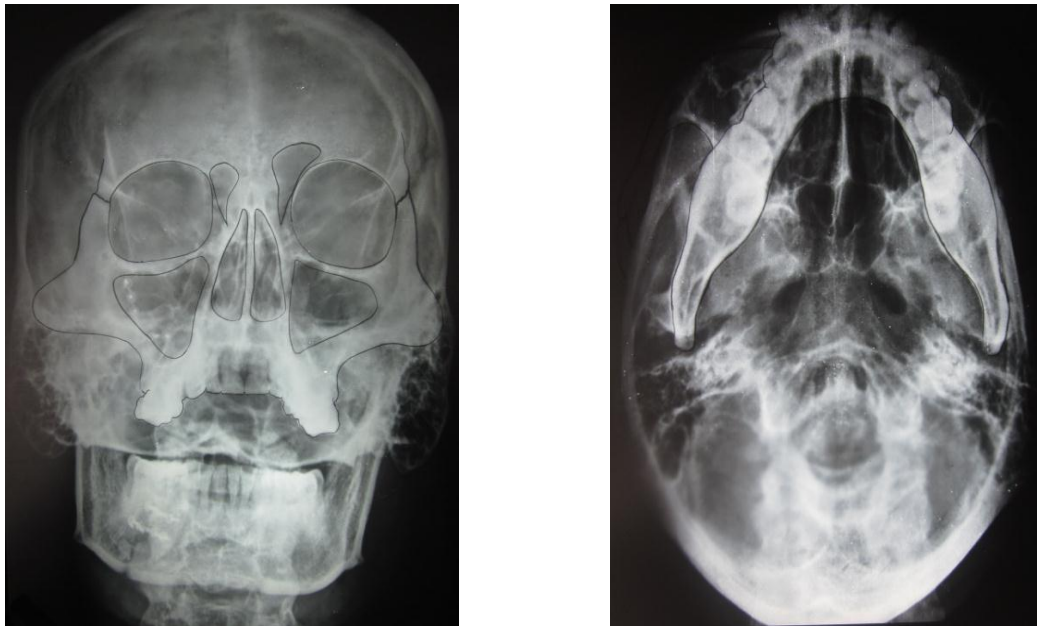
TRACING - IMMEDIATE POST OPERATIVE RADIOGRAPHS
